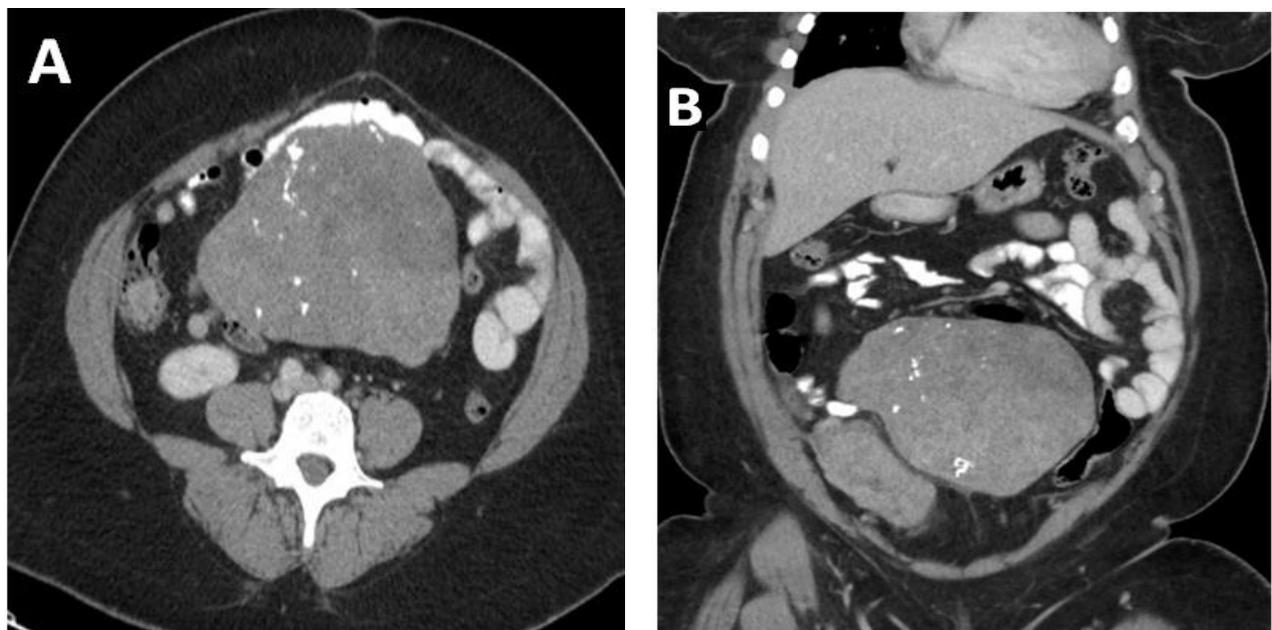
CT of the abdomen and pelvis with contrast. A) Multiple large uterine and exophytic uterine masses with calcifications. B) The largest mass creates a mass effect in the abdomen on the bowel.
